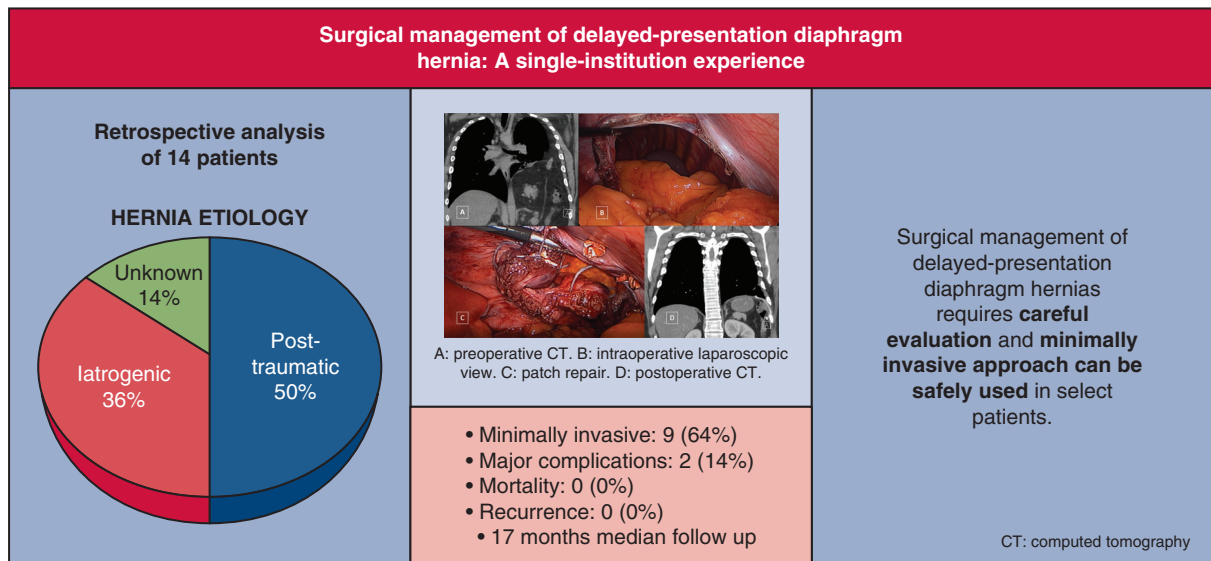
Summarizing objectives, methods, results, and outcomes of this study. CT, Computed tomography.
